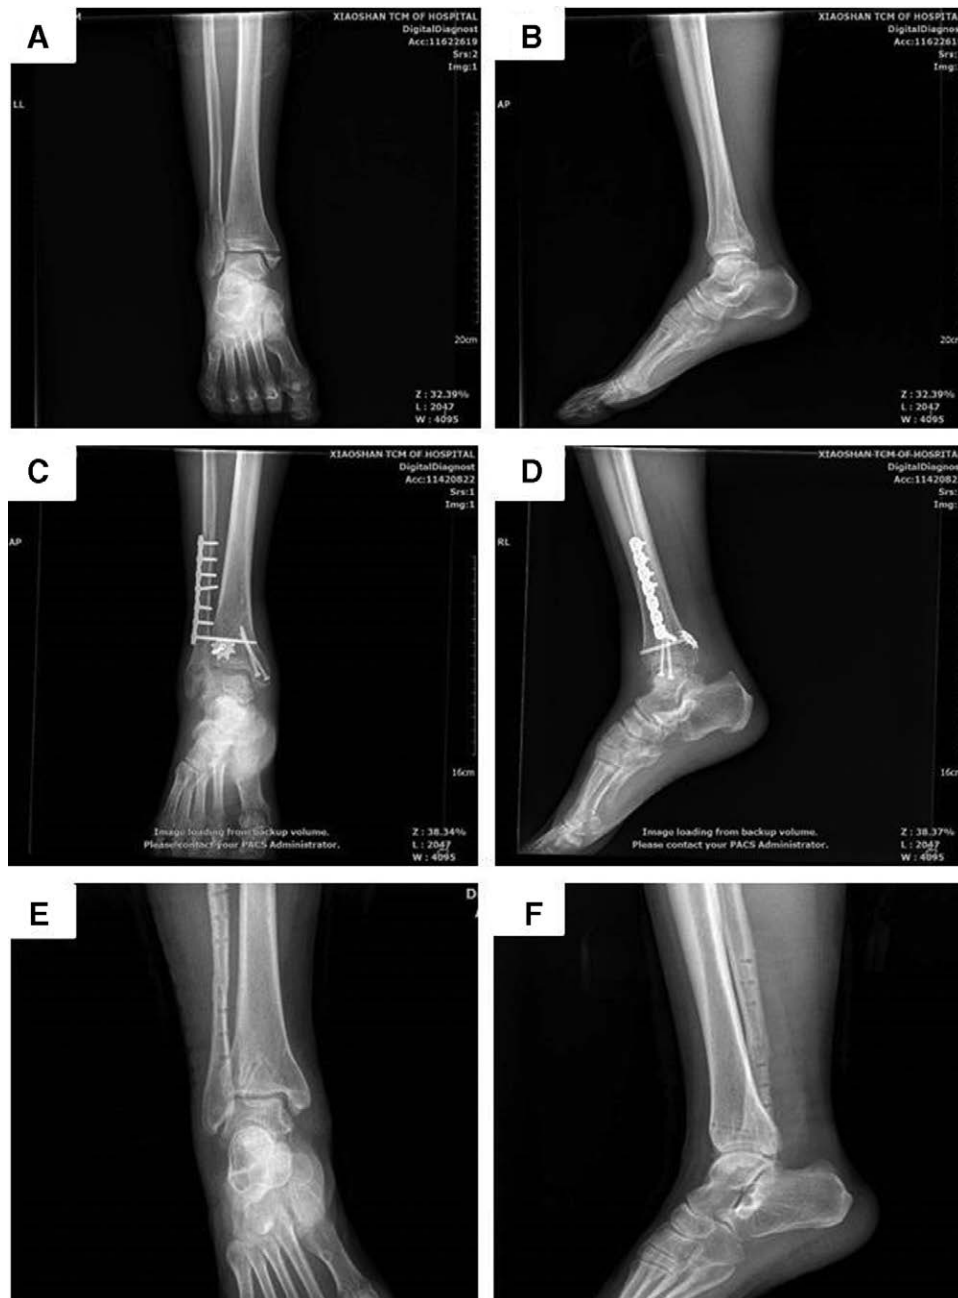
Male, 66-years-old, left ankle fracture caused by sprain (type B of Weber classification). (2a, 2b) Preoperative AP and lateral X-ray films showed the distal fibula oblique fracture in distal tibiofibular syndesmosis, and accompanied with osteoporosis. (2c, 2d) Postoperative AP and lateral X-ray at the 1st month after operation showed the distal fibula fracture was fixed with an anatomical locking plate. (2e, 2f) At the 14th month after the operation, the internal fixation device was removed. AP and lateral X-ray films showed fracture was healed and the function of the ankle was well.
